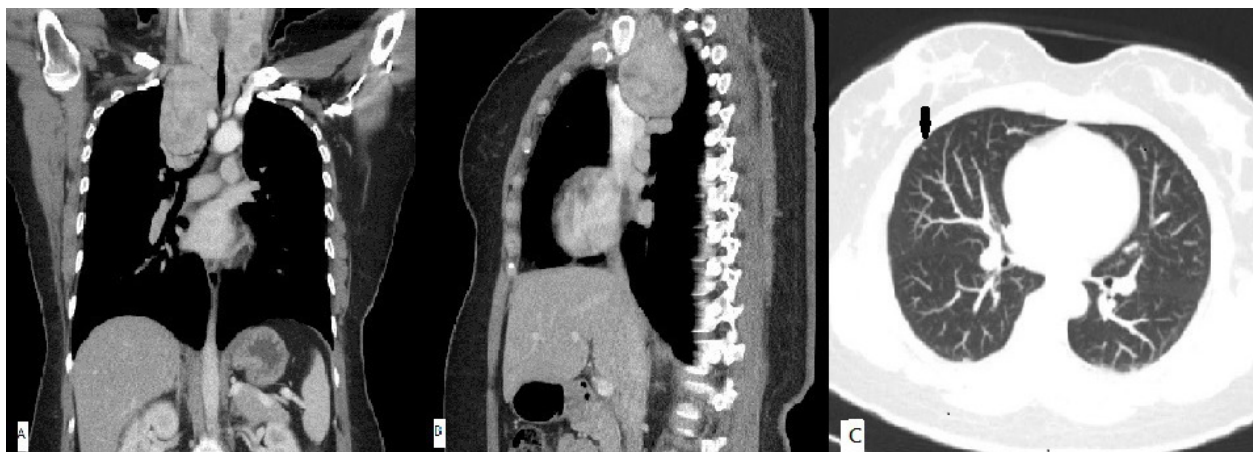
A. CT scan with contrast (coronal view) showing low-density nodules in bilateral thyroid glands, and the presence of a separate mediastinal mass. B. CT scan with contrast (sagittal view) showing low-density nodules in bilateral thyroid glands, and the presence of a separate mediastinal mass. C. CT scan with contrast (axial view) showing a nodule (arrow) in the RML of the lung.
